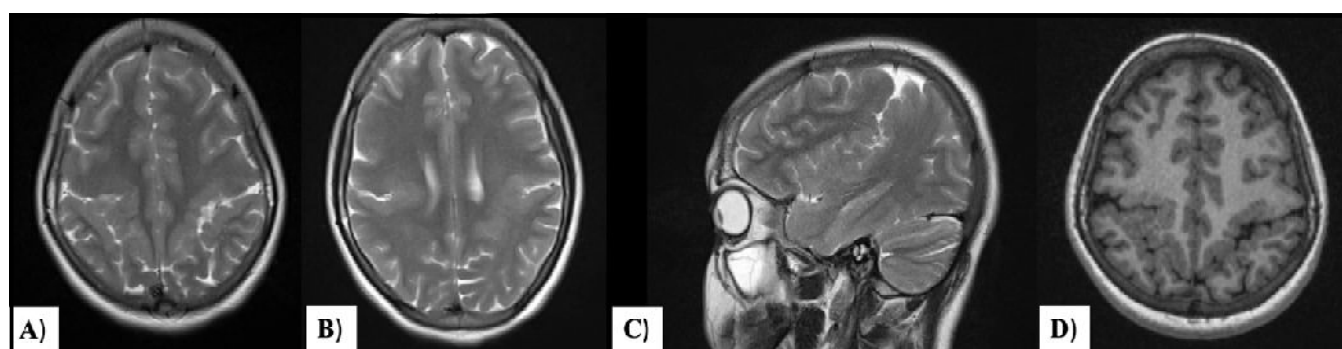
Bilateral Perisylvian Syndrome; Axial T2W (A,B), Sagittal T2W and Axial T1W MRI images reveal vertically oriented and widened sylvian fissures continuous with central/postcentral sulcus and presence of perisylvian Polymicrogyria.
